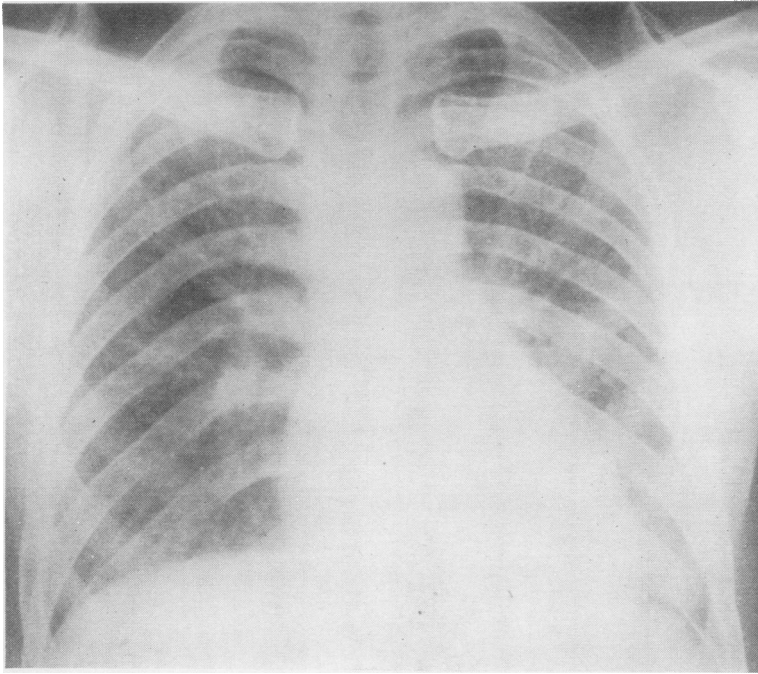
Radiograph of the chest of patient S.McK., showing widespread mottling.
